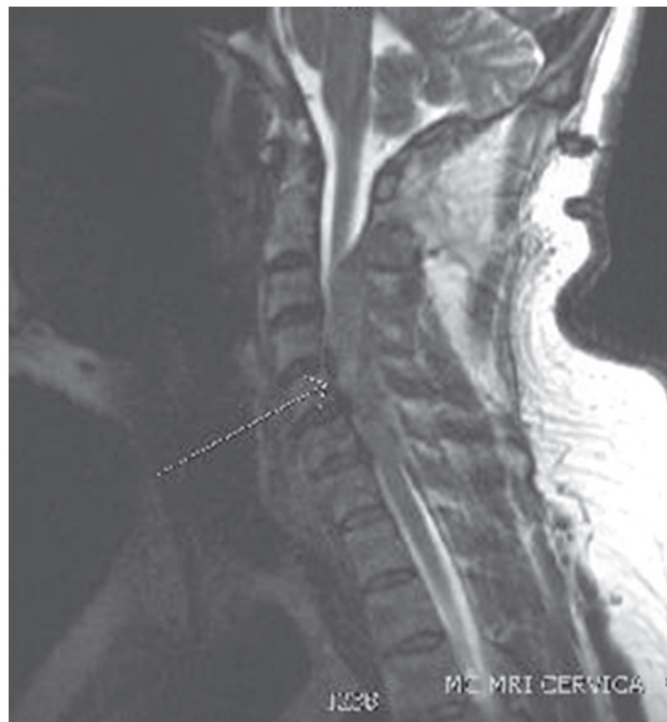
Pre-surgery sagittal cut MRI C-spine.
